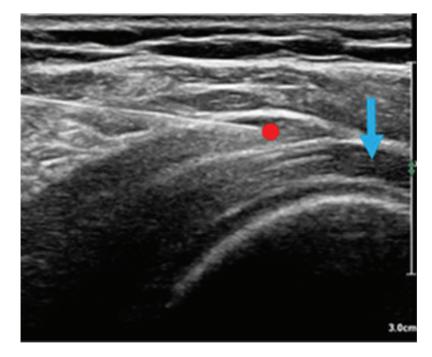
Ultrasound-guided sub acromial bursa injection. The blue arrow indicates the tendon tear and the red dot indicates the needle tip.
